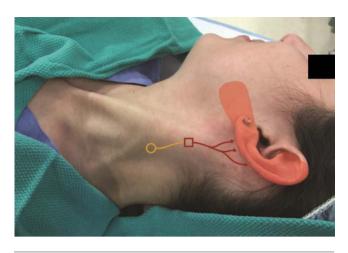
Image depicting origin of greater auricular nerve (GAN) in cervical plexus (yellow circle), typical location of ultrasound guided nerve block (red square), and areas anesthetized by the GAN block (highlighted area). Image published with permission from volunteer model.
